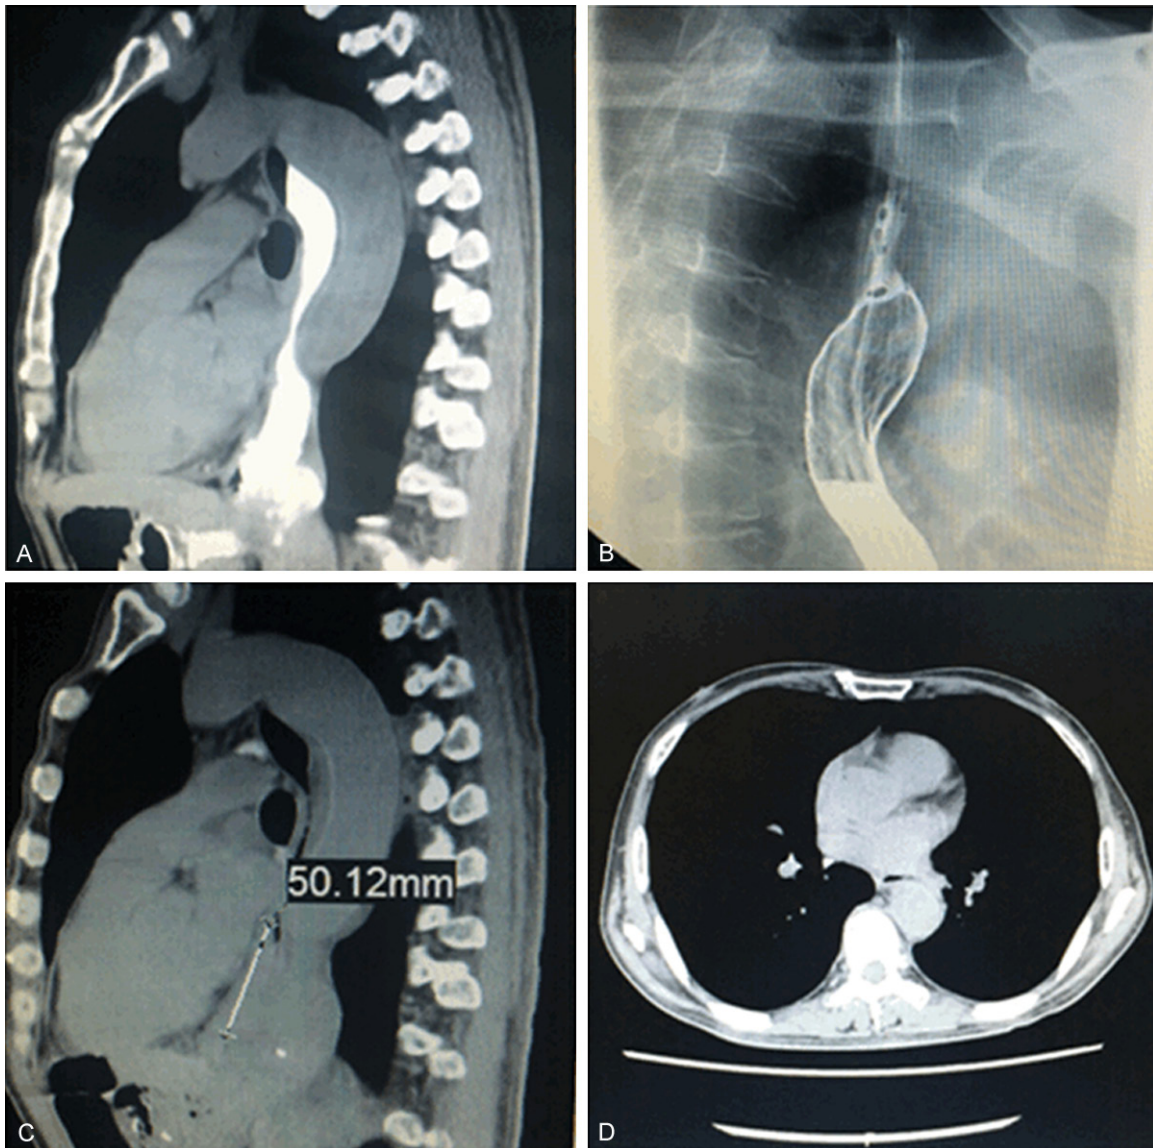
A. The baseline CT of post-operation shows no thickening of the esophagus wall, the contrast agent was observed accumulated to the upper esophagus. B. Barium swallow examination on September 2013 showed beaded oval filling defects above the Esophagus-Jejunum anastomosis. C. CT scan on September 2013 shows thickening of the esophagus wall 5 cm above the Esophagus-Jejunum anastomosis. D. CT scan on September 2013 shows no thickening in the upper esophagus.
